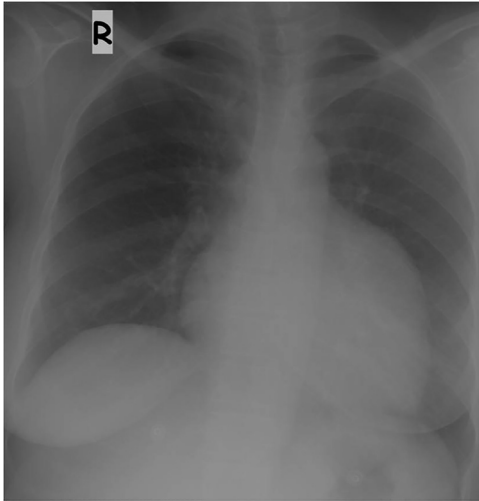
Postero-anterior radiograph; left ventricle and heart dimensions are increased.
